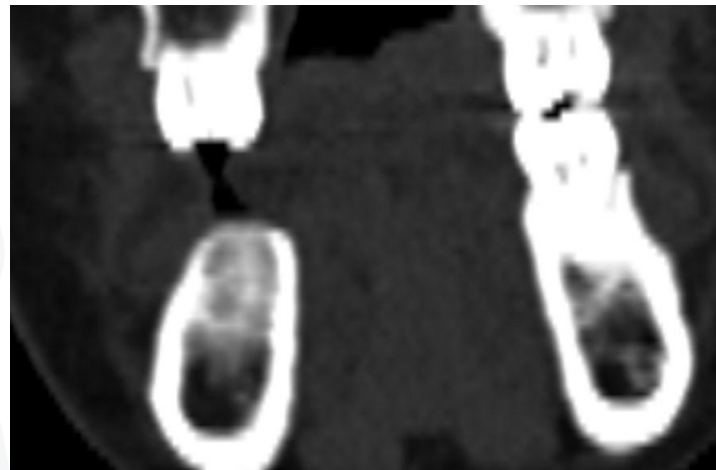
CT scan at the site of the 36th tooth; D3 – compact porous fabric, looseness in the spongy layer
